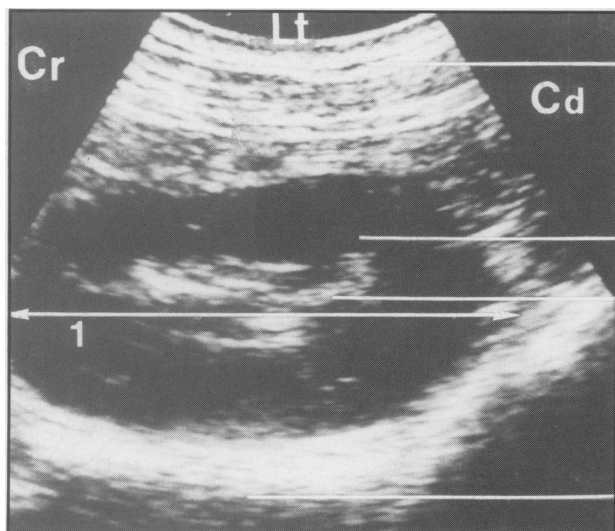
Ultrasonogram of a medial longitudinal section through the left kidney. 1 = length of the kidney; top line = abdominal wall; second line = renal parenchyma; third line = renal sinus; bottom line = ruminal wall; Cd = caudal; Cr = cranial; Lt = lateral.
